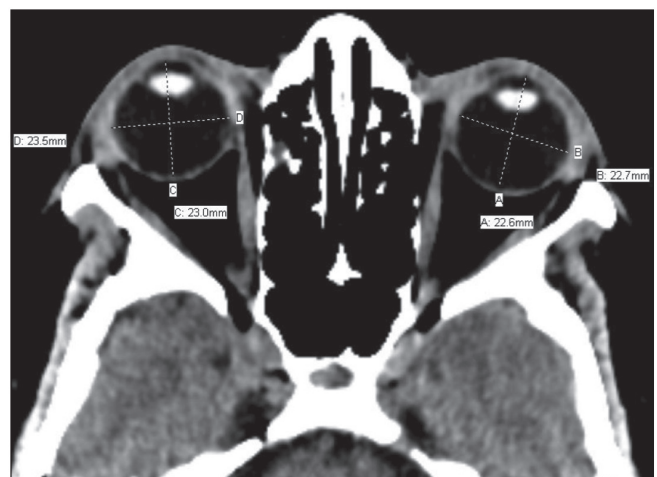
Axial CT of the eyeballs/globes at the level of the lens showing the anteroposterior diameters (lines A and C) and transverse diameters (lines B and D) of the eyeballs
